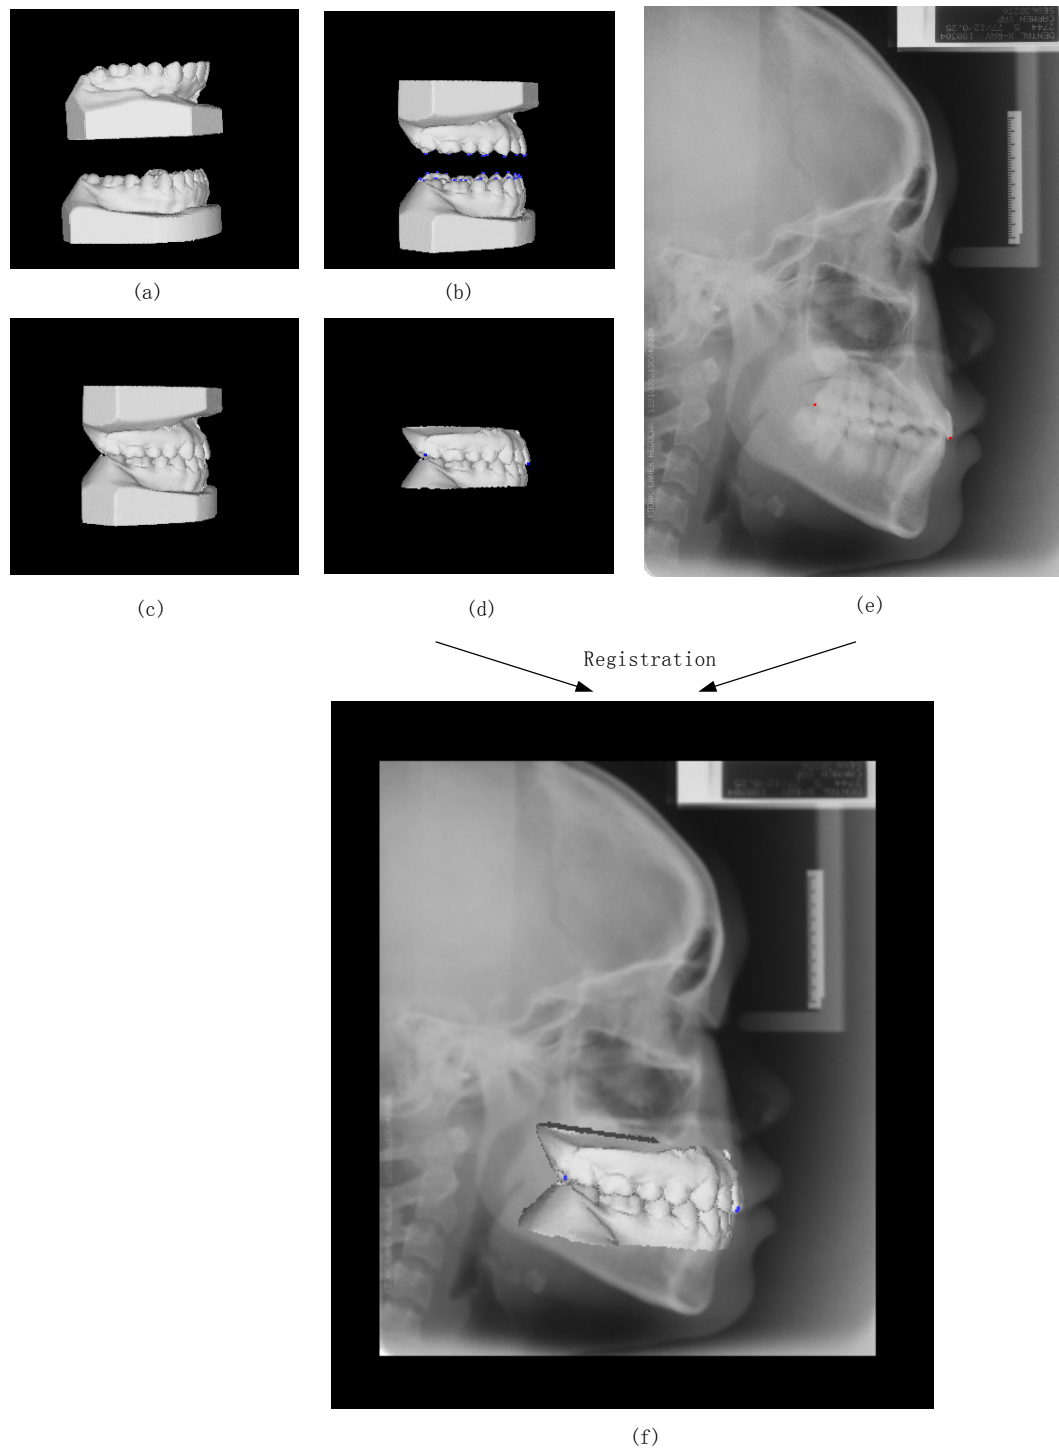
The registration result of dental casts and lateral cephalogram. Dental cast: (a) Initial position; (b) After rotation; (c) After translation; (d) Trimmed casts with landmarks. (e) X-ray with landmarks. (f) The registration result.
